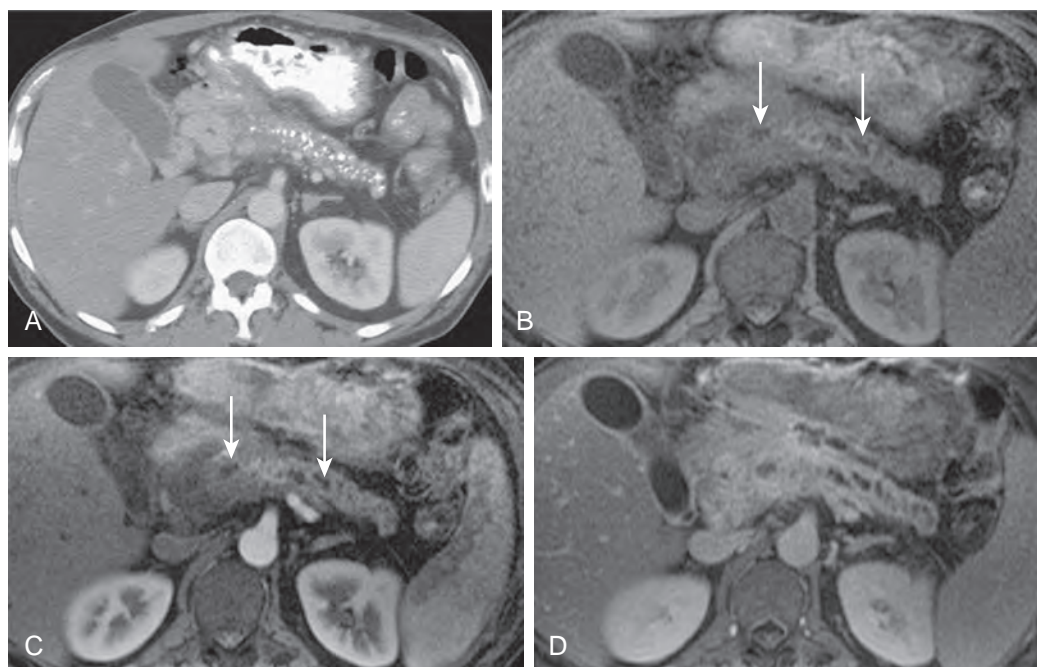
Chronic pancreatitis. A. Axial contrast-enhanced MDCT image shows pancreatic atrophy with multiple diffuse calcifications in a patient with chronic pancreatitis due to alcohol abuse. B. Axial T1-weighted fat-suppressed spoiled gradient-echo MR image shows decreased heterogeneous signal intensity of the pancreas and irregular dilation of the main pancreatic duct (arrows). C and D. Axial gadolinium-enhanced T1-weighted fat-suppressed spoiled gradient-echo MR images show decreased pancreatic enhancement during the arterial phase (C) and delayed enhancement in the venous phase (D) related to fibrosis due to chronic pancreatitis. Dilated pancreatic duct (arrows in C) is more clearly visualized after gadolinium enhancement. (B-D from Miller FH, Kepcke AL, Wadhwa A, et al: MRI of pancreatitis and its complications: Part 2, chronic pancreatitis. *AJR Am J Roentgenol* 183:1645–1652, 2004. Reprinted with permission from the American Journal of Roentgenology.)
